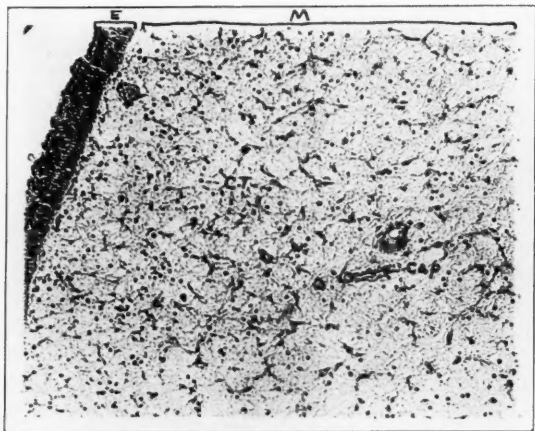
Nasal polyp ($\times 135$). E—Epithelium. M—Myxomatous tissue. CT—Connective tissue cells. Cap—Blood capillaries.
